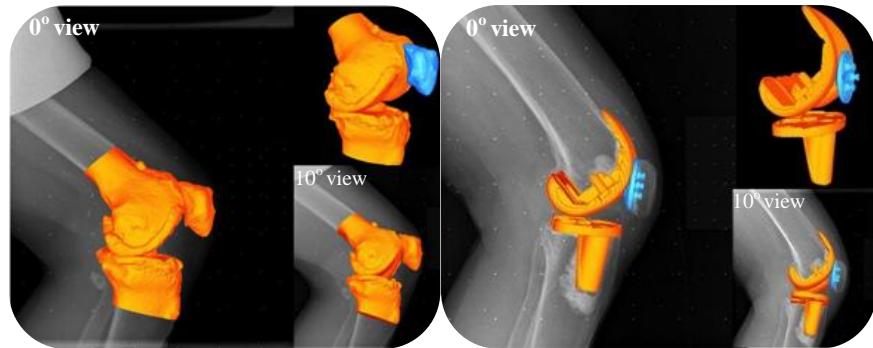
Performing the 2D-3D image matching to the biplanar (pure sagittal and 10° below sagittal) radiographs for the joint line calculations at 0°, 45° and 90° knee flexion.
